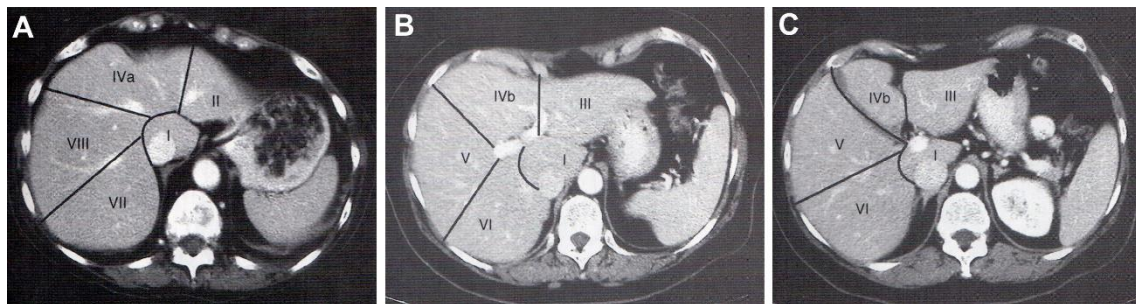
“Hepatic segmental anatomy as shown by CT. A, At the level of the hepatic veins. B, At the portal vein bifurcation. C, Below the hepatic hilus. Roman numerals stand for liver segments.” (Source: Blumgart LH, Hann LE. *Surgical and Radiologic Anatomy of the Liver, Biliary Tract, and Pancreas*. In: Blumgart LH. (ed.), *Surgery of the Liver, Biliary Tract, and Pancreas*. Saunders, Philadelphia, 2007: 9.).
